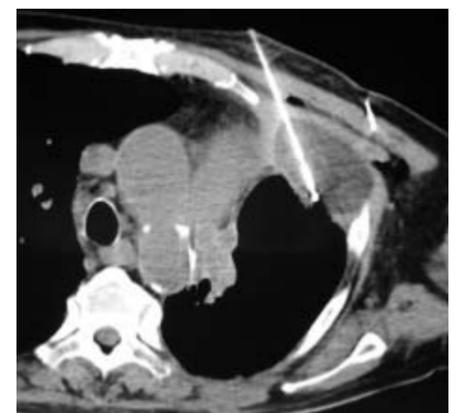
Cryoablation of painful thoracic wall metastasis. Precise monitoring of the ice ball with CT. Cryoablation is less painful compared to radiofrequency ablation.
